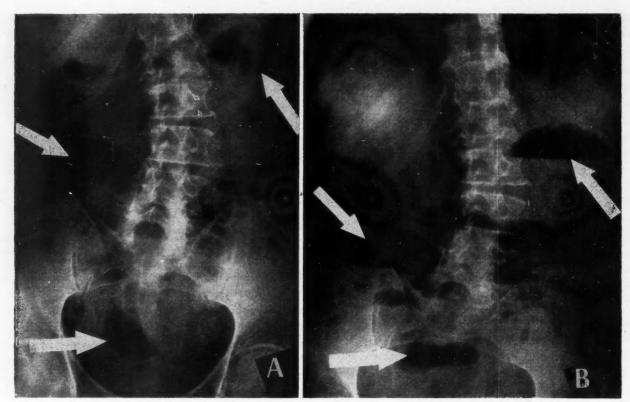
Radiographs of abdomen taken preoperatively in case described, which show limited mobility of gas-filled loops. A.—Patient supine. B.—Patient standing.
